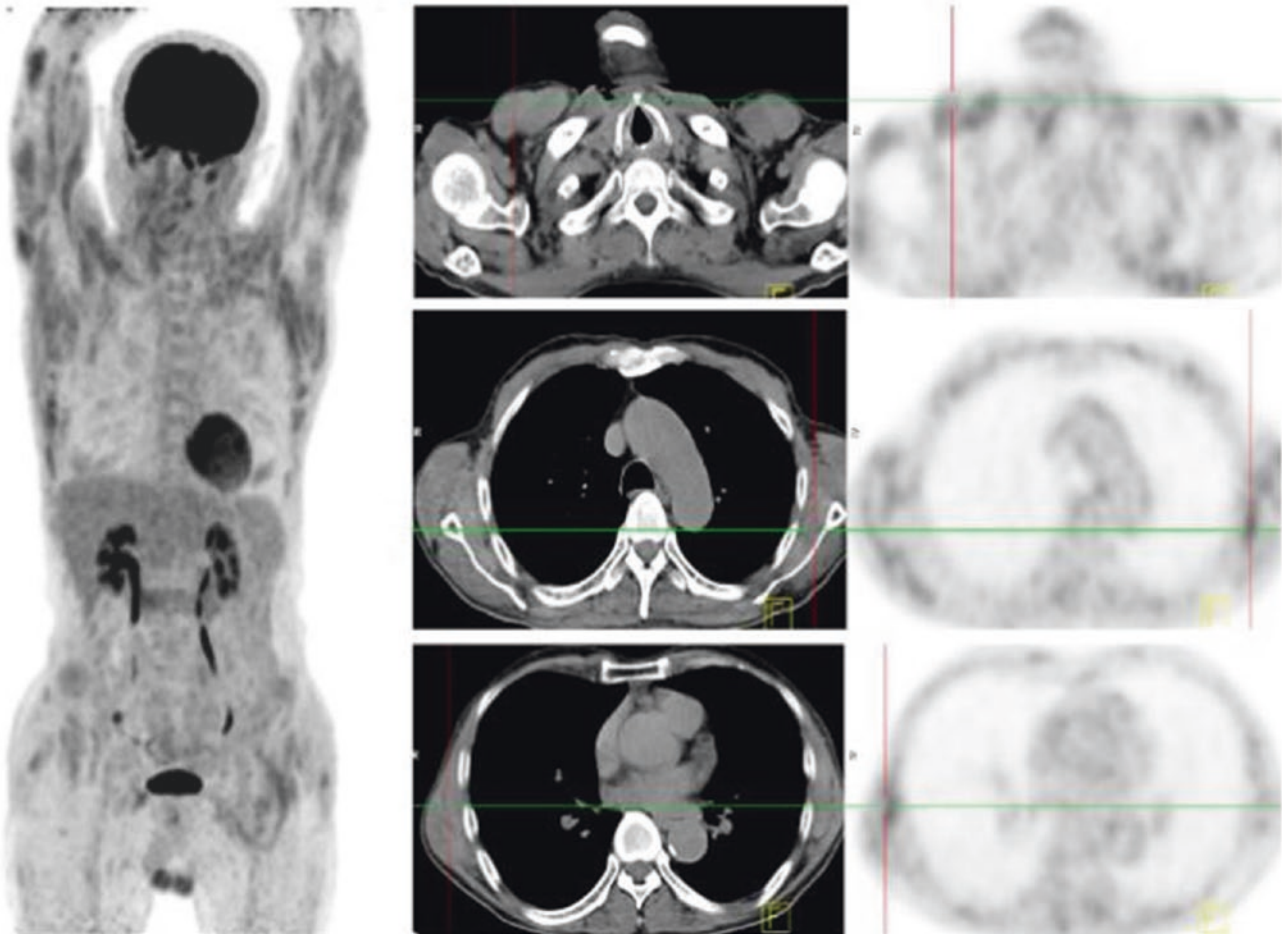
^{18}F -FDG PET/CT image
